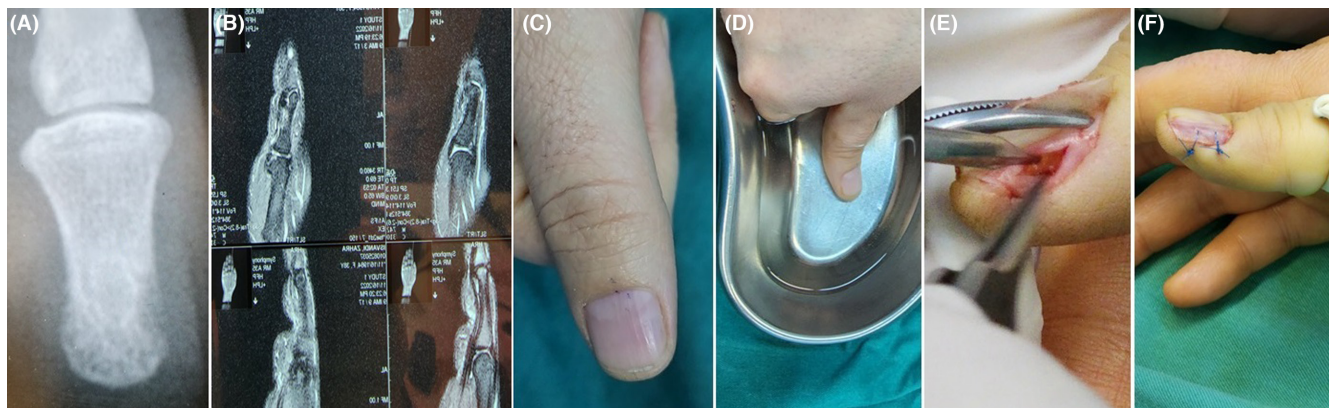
The subungual glomus tumor area was examined by a plain radiography (A-P view; A), followed by a T-1-weighted CT scan (B) and physical examination (C) of the thumb. After softening the nail plate by placing the distal phalanx of the thumb in a warm water bath at 55°C (D), the tumor was removed (0.2×0.3 cm) (E), and the area was sutured (F).
